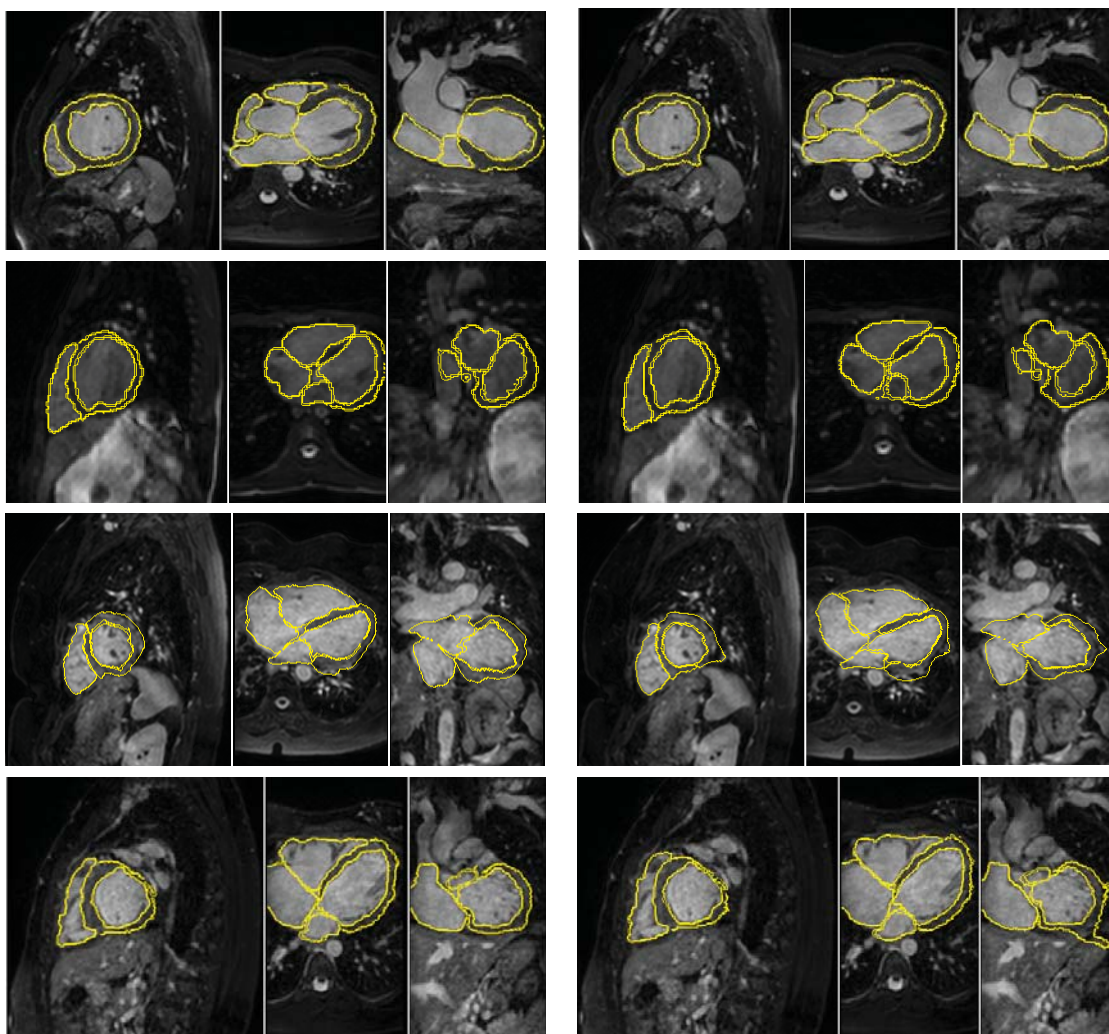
Three views, sagittal, transverse, coronal views of segmented contour superimposing on the MR images. These are four random examples of using the LARM_ACPS registration scheme (left) and the LARM_FFDs scheme (right).
